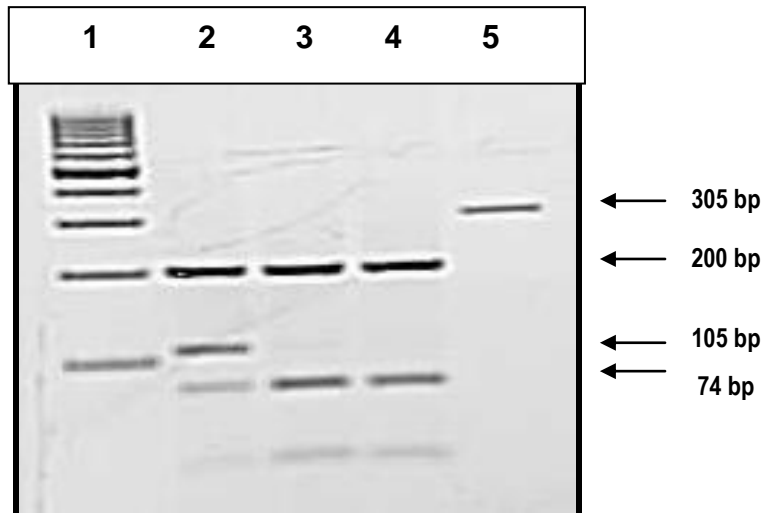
Acil* restriction enzyme analysis of c.682+49 C>T in the amplicon containing exon 9 resolved on a 3% (w/v) agarose gel. Lane 1 = 100 bp molecular weight marker (O'Generuler™, Fermentas); lanes 2 = CT, lanes 3, 4 = CC, lane 5 = undigested fragment (305 bp).
